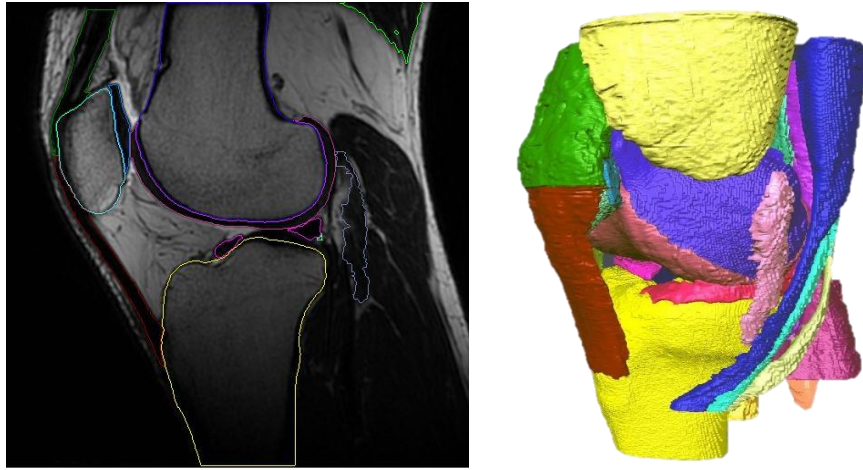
Left: Segmentation process on the knee high-resolution MRI, Right: Segmented surfaces of the joint articulation, ligaments, tendons, and muscle insertions.
